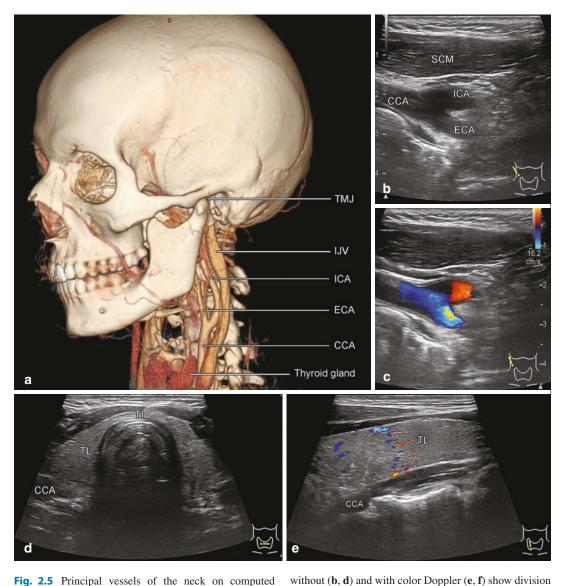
Principal vessels of the neck on computed tomography VR—volumetric reconstruction (a) with a common (CCA), internal (ICA) and external carotid artery (ECA) and internal jugular vein (IJV). Ultrasound
